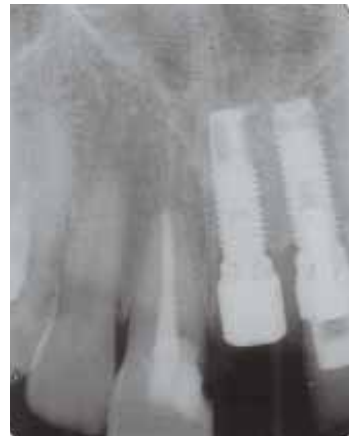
A radiograph showing the 5mm transmucosal abutment on the implant replacing the upper left central incisor
